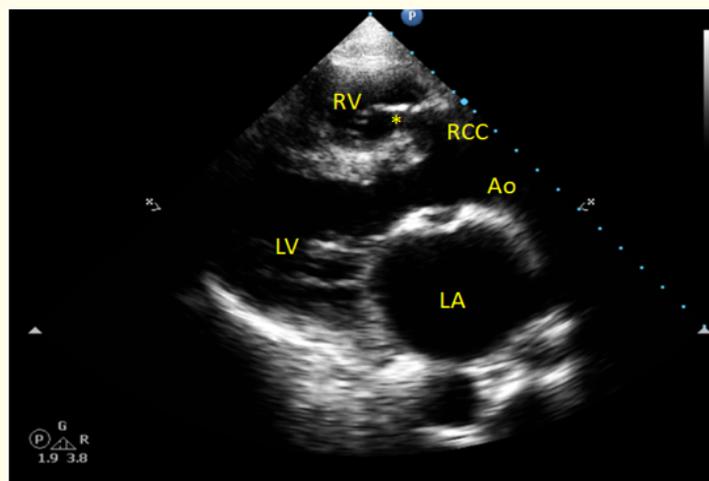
2D transthoracic echocardiogram parasternal long axis view showing aneurysm of sinus of Valsalva arising from right coronary sinus with classical windsock deformity. LA: Left Atrium; LV: Left Ventricle; Ao: Aorta; RCC: Right Coronary Sinus; RV: Right Ventricle; *: Classical Windsock Deformity of RSOV.
